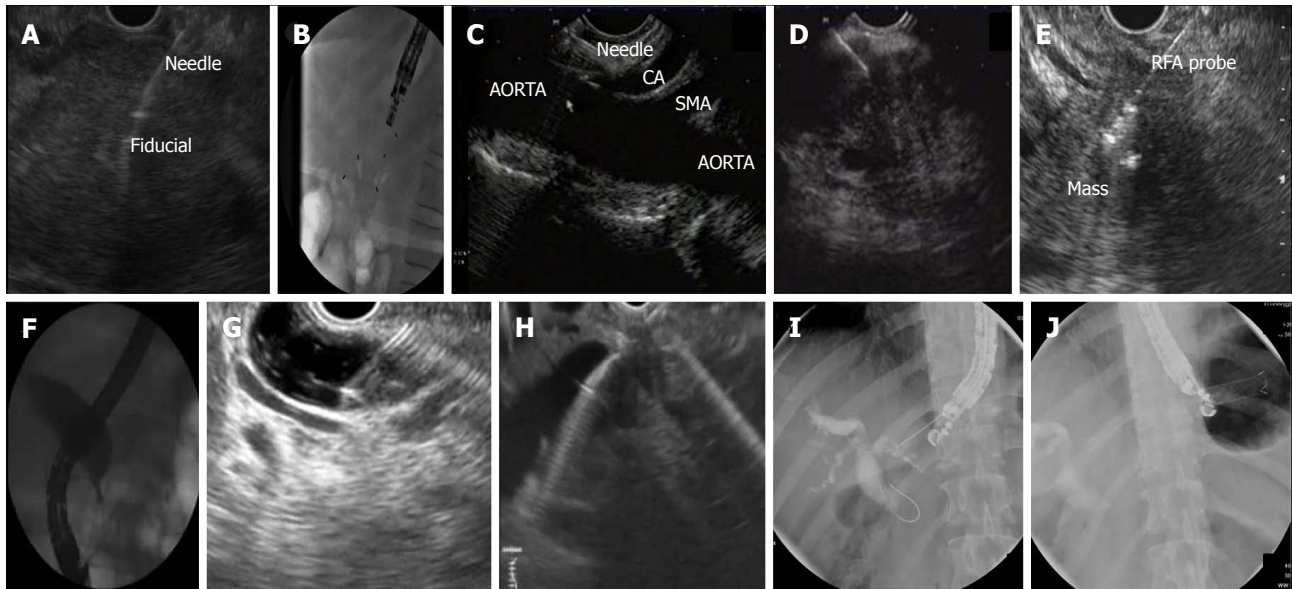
Endoscopic ultrasound guided interventions. A and B: fiducial placement for mass in the head of pancreas (HOP); C: celiac plexus neurolysis (CA-celiac artery, SMA-superior mesenteric artery); D: fine needle aspiration of mass in the HOP; E radiofrequency ablation (RFA) of mass in the HOP; F,G and H: choledochoduodenostomy for biliary stricture due to mass in the HOP; I and J: hepaticogastrostomy and placement of metal stent.
